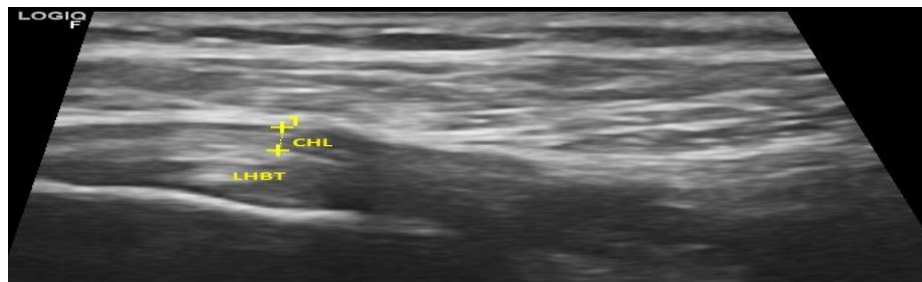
Oblique axial ultrasound image of rotator interval in a patient with adhesive capsulitis showing thickened CHL (coracohumeral ligament) measuring 2 mm. LHBT: Long head of biceps tendon.
